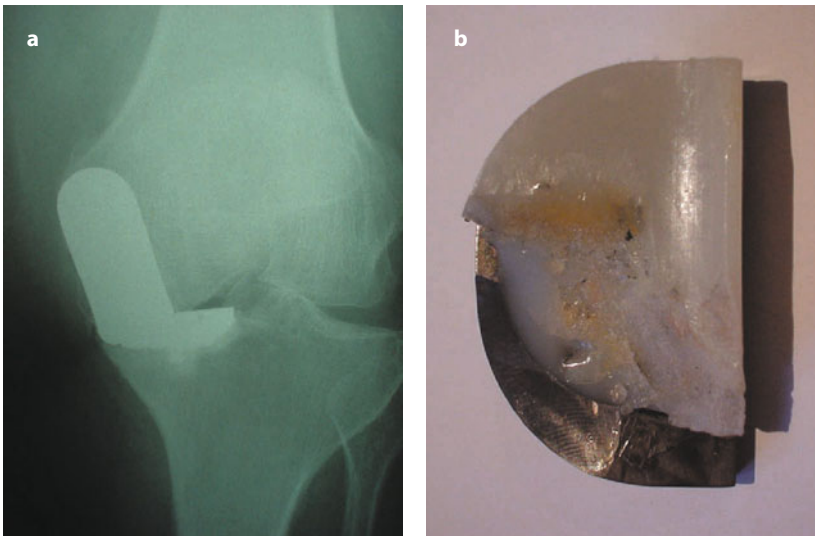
a Radiograph showing significant malpositioning of UKR prosthesis leading to edge loading. b Explanted tibial prosthesis from the clinical case in 4.12 a. Accelerated polyethylene wear is shown as a direct result of malposition of the prosthesis and edge loading
